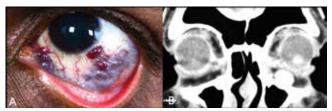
(A) Left eye conjunctival venous malformation (B) Coronal CT shows the presence on an irregular isodense mass in the inferior left orbit with a hyperdense well-circumscribed lesion along the orbital floor, suggestive of phlebolith within the orbital varix.
